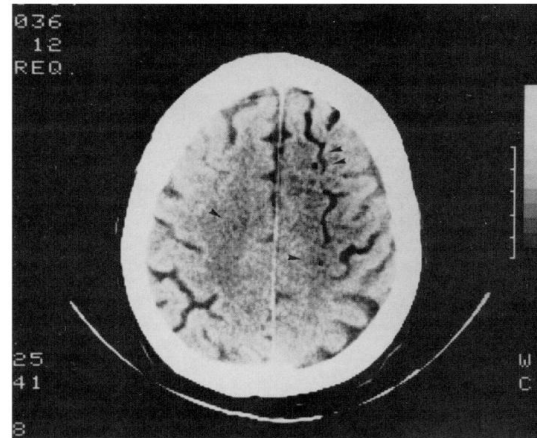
Cerebral computed tomography 3 hrs after onset of signs and symptoms. Multiple air bubbles are seen more prominently in the right hemisphere subarachnoid vessels.
